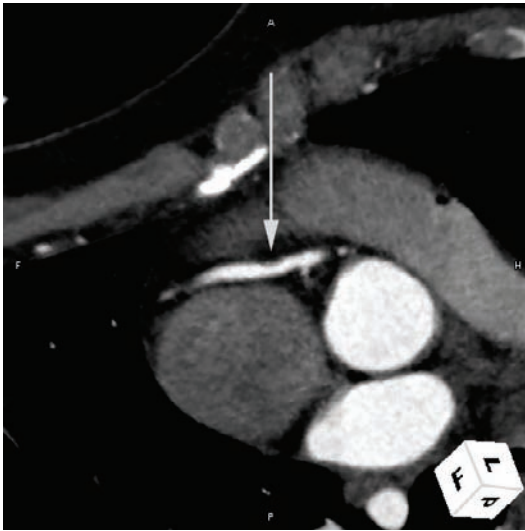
Curved multiplanar imaging shows lesion in the right coronary artery demonstrated by multidetector row computed tomography (arrow).
